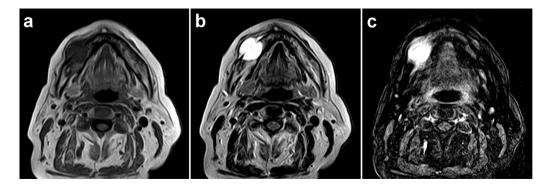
MRI showing a round-shaped homogeneous intensity mass expanding from the mandible. (a) The lesion shows low intensity on a T1-weighted image. (b) The lesion shows high intensity on a T2-weighted image. (c) The lesion shows high intensity on a STIR image.
